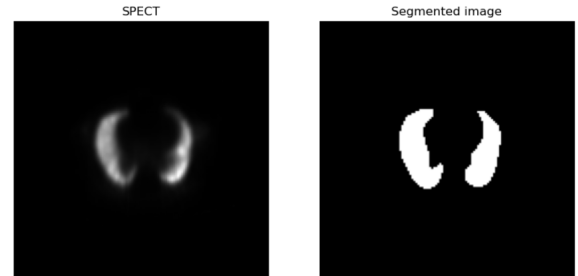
SPECT slice segmentation
